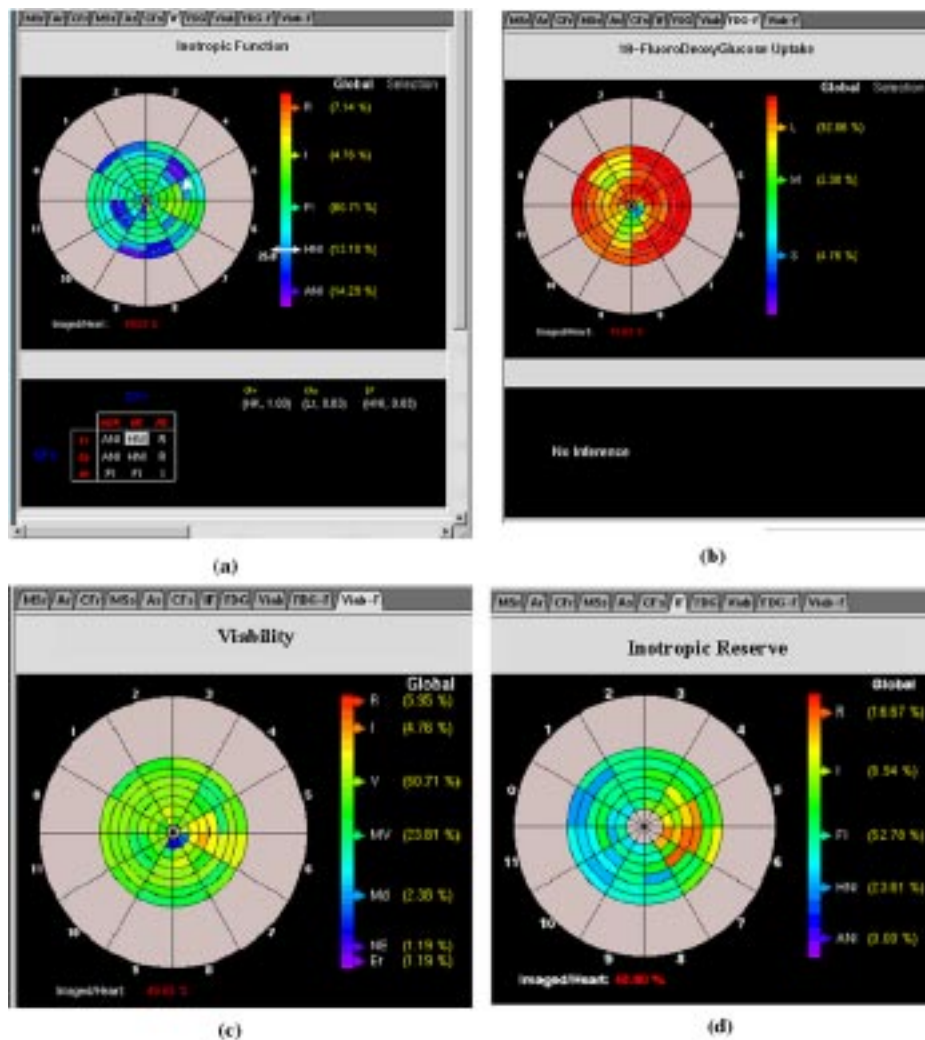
CAD output for a patient with a small infarct in the apical region and a global contractile function defect. The polar maps of all the system parameters are presented in a notebook screen. Each page of the notebook shows the polar map and the corresponding inference rules (if any). By a simple click on a sector (see arrow) the exact value of the sector and the rule(s) used to infer it are displayed. (a) *IR* polar map. This patient presents a relatively good *IR*. (b) FDG-uptake polar map. Only a small defect is present at the apical region (4.76%). (c) Viability polar map. The CAD derived 61% of viable sectors and 24% of metabolically viable sectors. (d) *IR* after reperfusion. The heart shows a global *IR* improvement.
